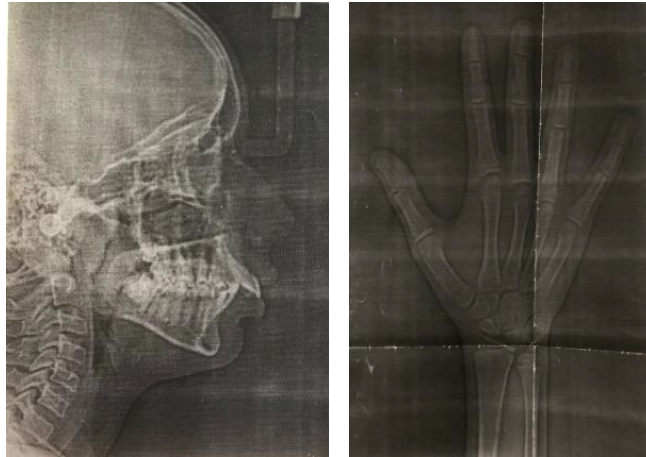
Pretreatment Lateral Cephalogram and Handwrist radiograph
